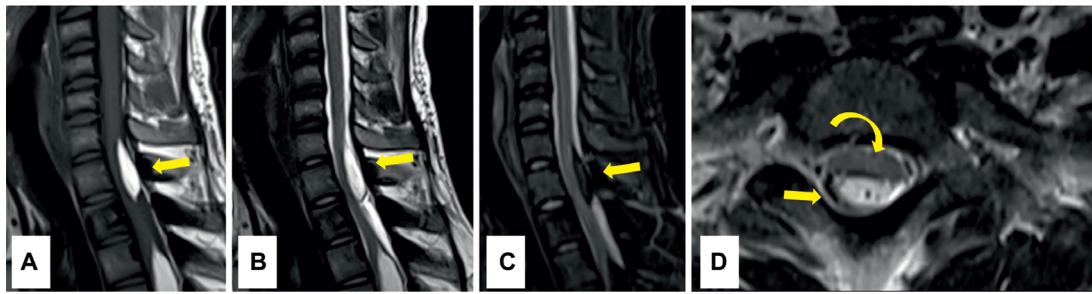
Sagittal T1 (A), T2 (B), short tau inversion recovery (STIR) (C) images—well-defined dorsal intradural lipoma (arrows) at C7 to T1 level, measuring 27 × 7mm, hyperintense on T1, T2-weighted images, hypointense on STIR images. Axial T2 (D) image—cord displaced anteriorly (curved arrow) without myelomalacia.
